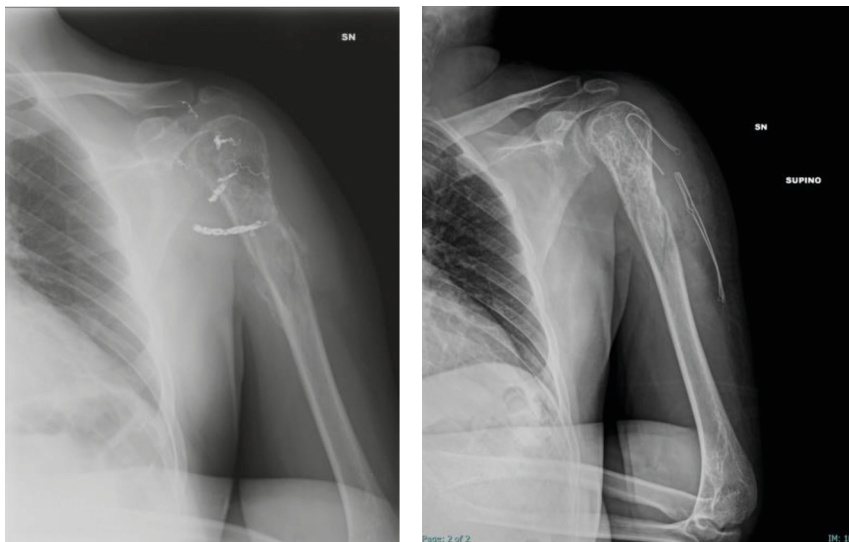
X-rays with a pathological fracture at the proximal humeral
